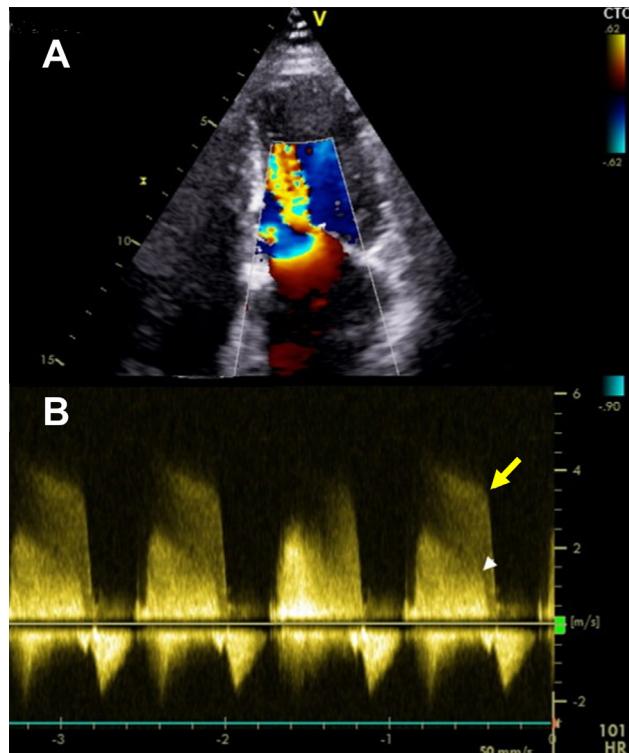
Mixed valve disease with rheumatic AR and MS. (A) Color Doppler and (B) CW Doppler spectral envelope of the mitral inflow (arrowhead) in apical 4-chamber view, demonstrating that the inflow jet through the funnel-shaped, stenotic MV orifice can be directed toward the interventricular septum, mimicking AR (long arrow) which lasts longer in diastole.
